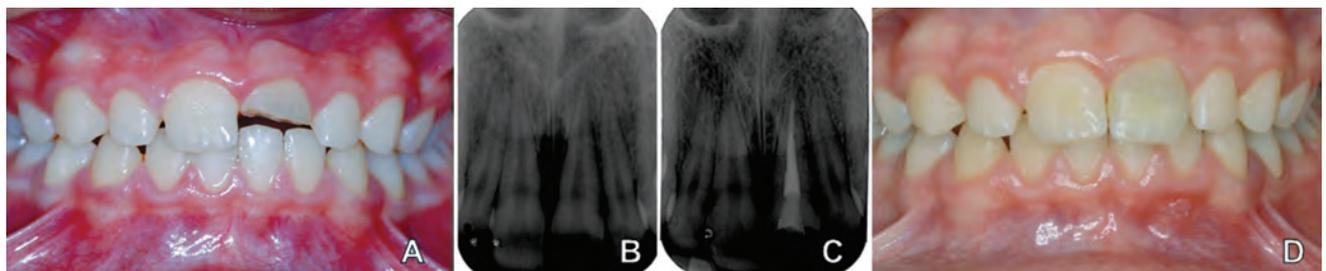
(A) Intra oral aspect of the first case; (B) Radiographic aspect before treatment; (C) Radiographic aspect after the endodontic treatment and before the reattachment of the dental fragment; (D) Final intra oral aspect of the first case.
